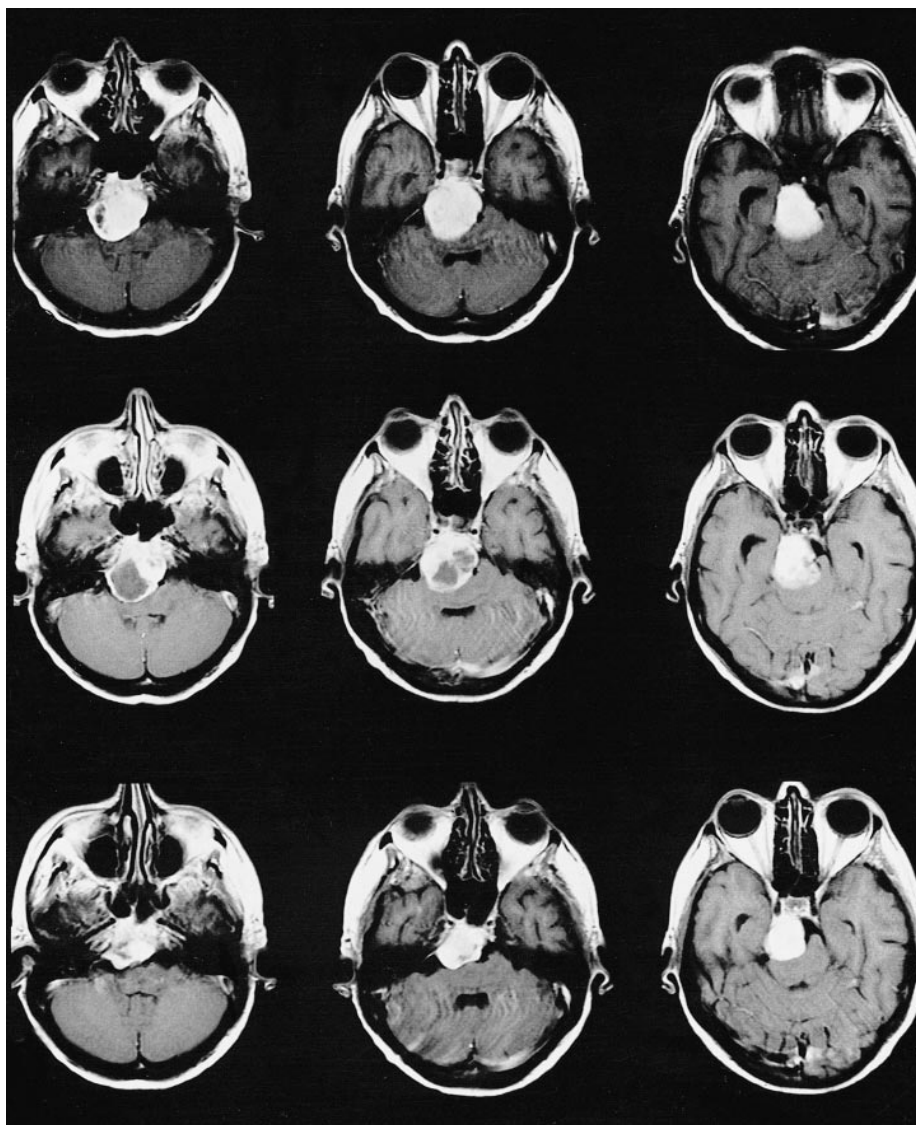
T1-weighted axial MR images of a clivus meningioma obtained after administration of contrast material.
